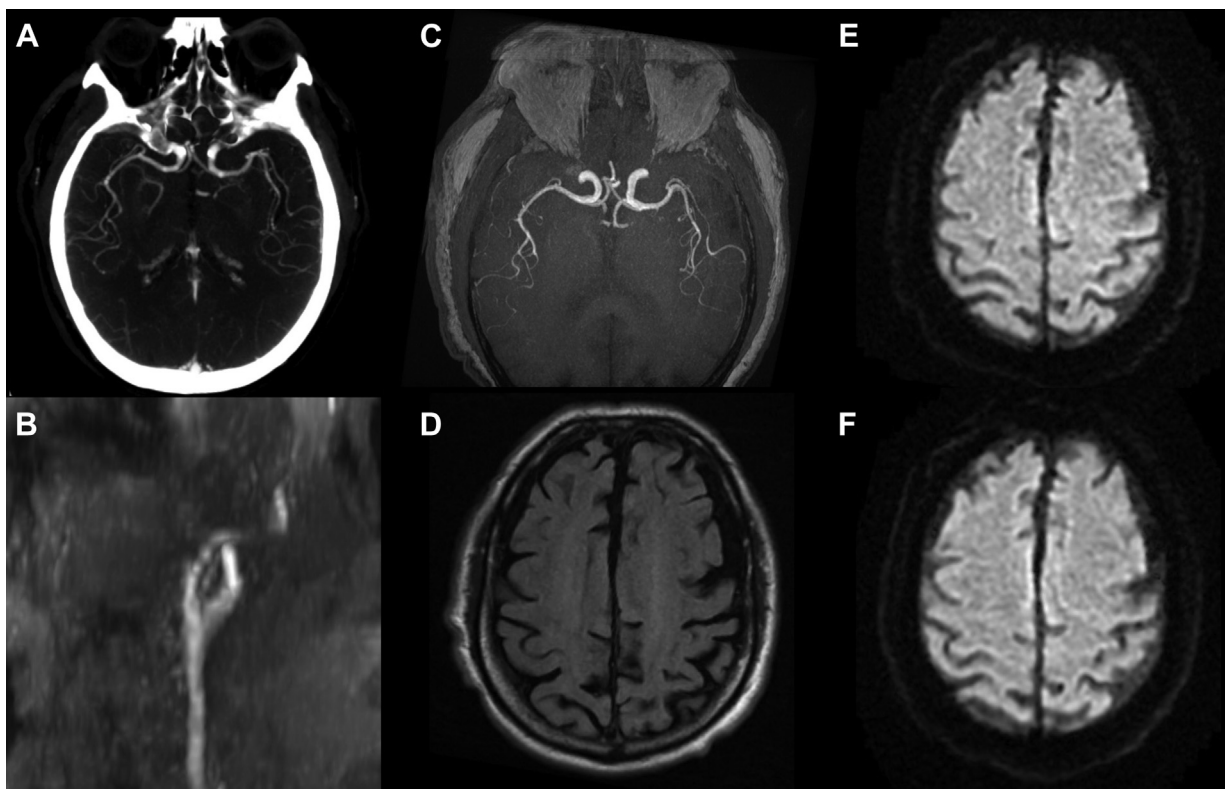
Before the patient's right carotid endarterectomy (CEA), computed tomography angiography of the head showed no evidence of intracranial arterial pathology with a symmetric appearance of the middle cerebral artery branch vessels in the Sylvian fissures bilaterally on axial thick slice reformats (A). On initial presentation to the emergency room on postoperative day 12 after carotid endarterectomy, magnetic resonance angiography of the patient's neck revealed a patent right carotid bifurcation as shown on time-of-flight coronal reformats (B). Magnetic resonance angiography of the brain was also performed, and axial thick slice reformats did not show a noticeable asymmetry in the middle cerebral artery branch vessels in the Sylvian fissures (C). Magnetic resonance imaging (MRI) of the brain conducted as a part of the study does not show any abnormal T2-weighted/fluid-attenuated inversion recovery (FLAIR) signal (D) or areas of acute infarct on diffusion imaging (E). When the patient presented again on postoperative day 14, magnetic resonance imaging of the brain was repeated and again showed no evidence of infarct (F).
